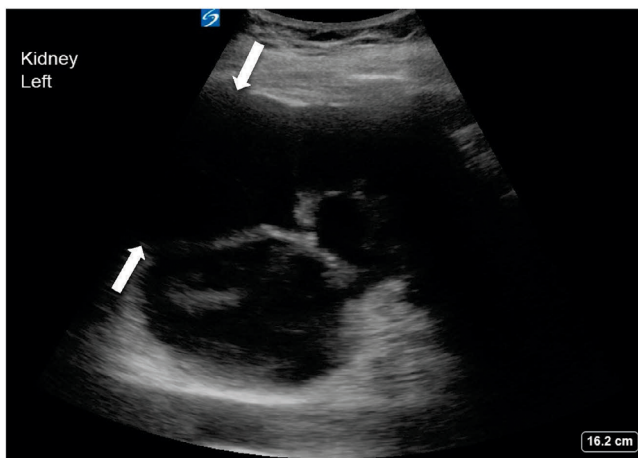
Ultrasound of the left kidney shows an enlarged fluid filled locule (white arrows) extending out of view.
